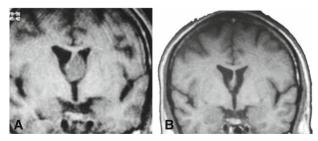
A Preoperative coronal T1-weighted MRI. B Postoperative MRI (after 1.5 years) shows no remnant or obstruction of the foramen of Monro
